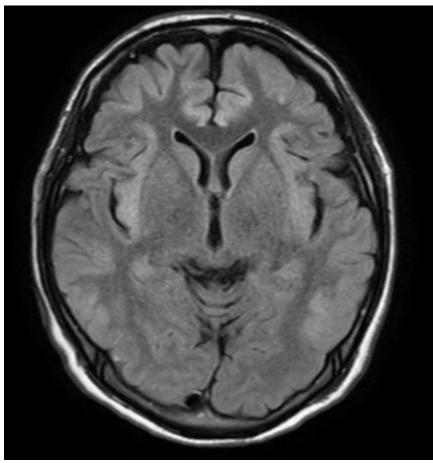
The findings of abdominal CT and brain MRI. (b) Transverse T2-weighted fast FLAIR imaging shows symmetric areas of increased signal intensity along the cortex and insula in both cerebral hemispheres.
